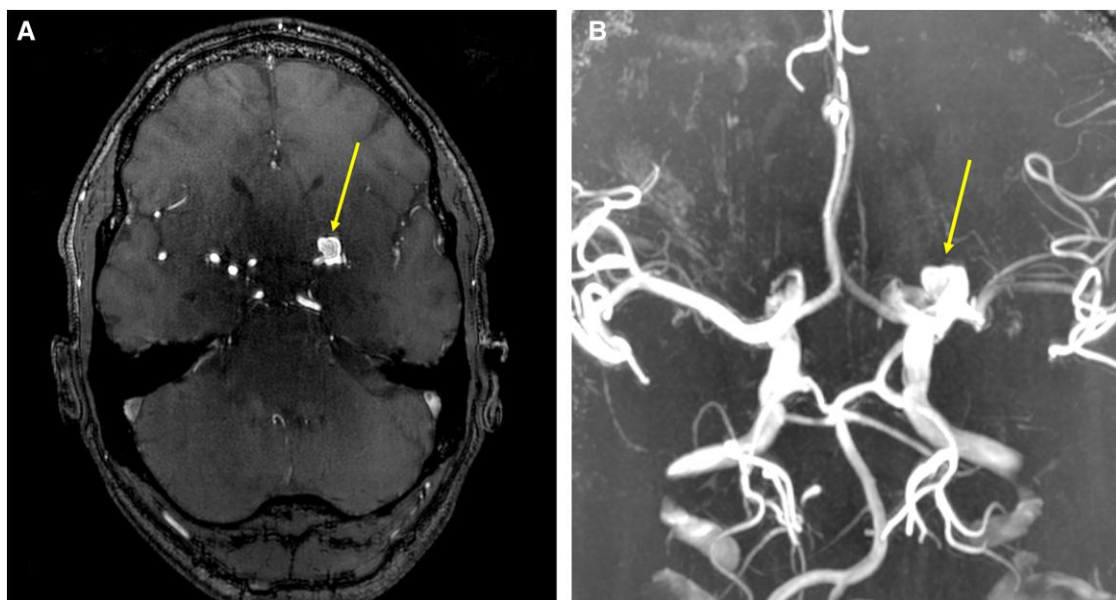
A 9 mm bifurcation aneurysm of the left internal carotid artery in a 43-year-old male patient with coarctation of the aorta. (A) The aneurysm was incidentally detected on a 7 T T1-weighted image (transversal view). (B) Subsequently, phase-contrast angiography was performed (coronal view). The aneurysm is indicated by the yellow arrows. The patient underwent successful neurosurgical clipping of the aneurysm.
